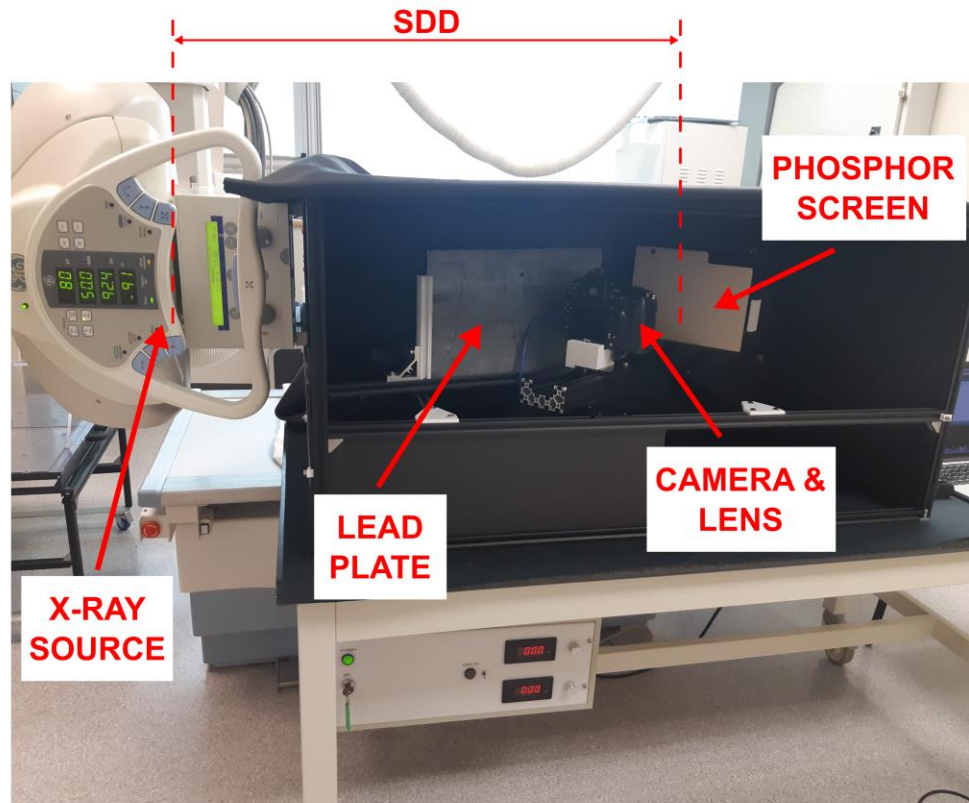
Experimental Setup using the General-Purpose X-ray Source. Note that the rotary stage is not visible as it is hidden behind the lead plate. The source-to-detector distance (SDD) was 60 cm.
